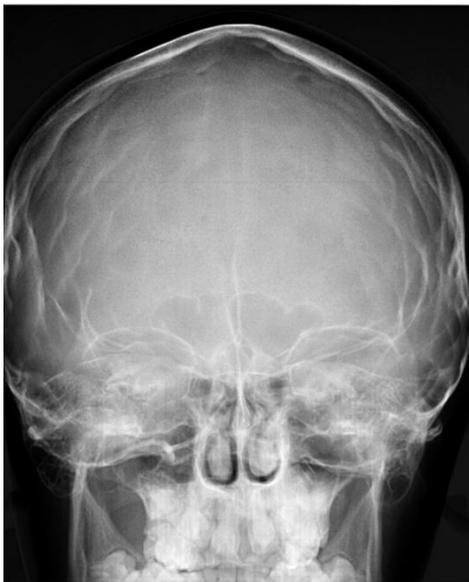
PA Skull radiograph showing beaten metal appearance.
